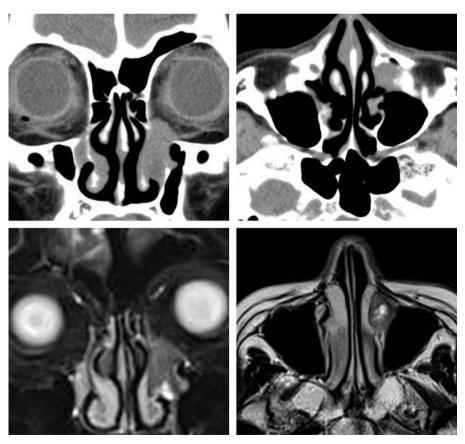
Computed tomography (CT) and T2-weighted magnetic resonance imaging (MRI) of the paranasal sinuses (before treatment). A CT image in the coronal section shows a mass with its center in the left nasolacrimal duct, extending to the orbital cavity. The axial section image shows enlargement of the nasolacrimal duct as compared with the right. The MRI scan in the coronal section shows a mass with low intensity corresponding to the site of the nasolacrimal duct. The coronal section image shows a high-intensity area internally, suggesting the presence of an internal tear component.
